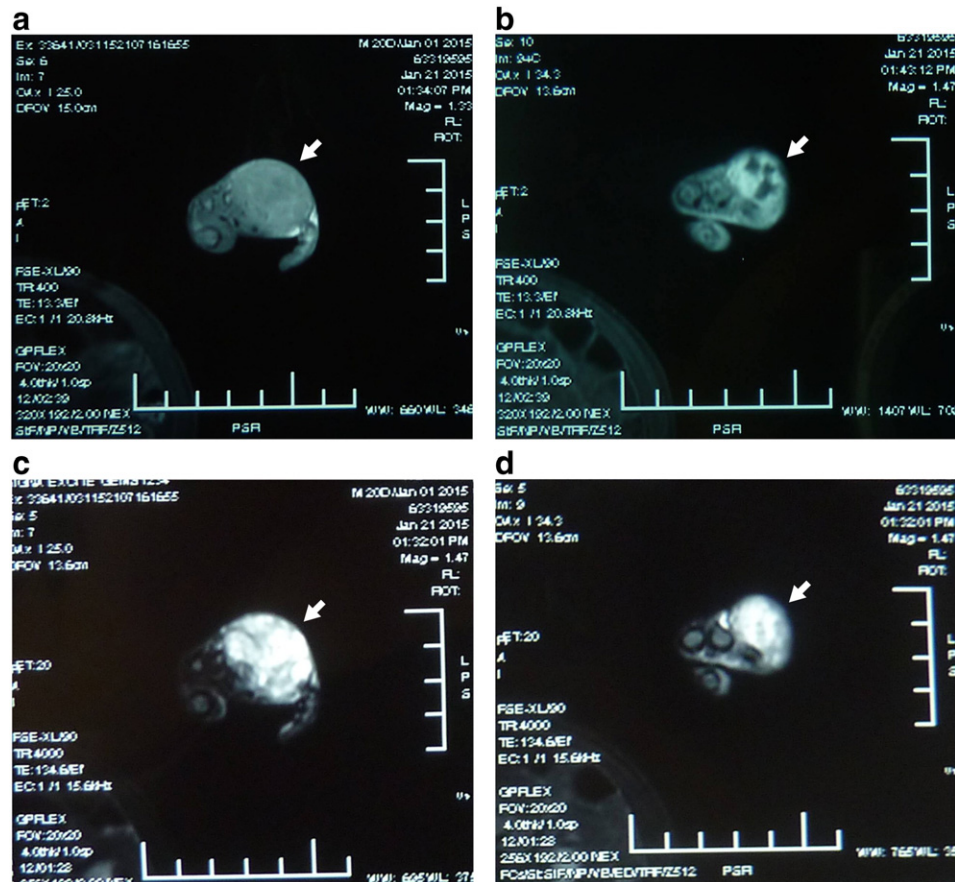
MRI appearances. a Sagittally, T1-weighted sequence shows heterogeneous isointense signal (arrow). b Horizontally, T1-weighted sequence shows peripheral enhancement and internal MRI degeneration (arrow). c (Sagittal) and d (Horizontal) T2-weighted sequences demonstrate heterogeneous T2 signal with central hyperintensity (arrows).
